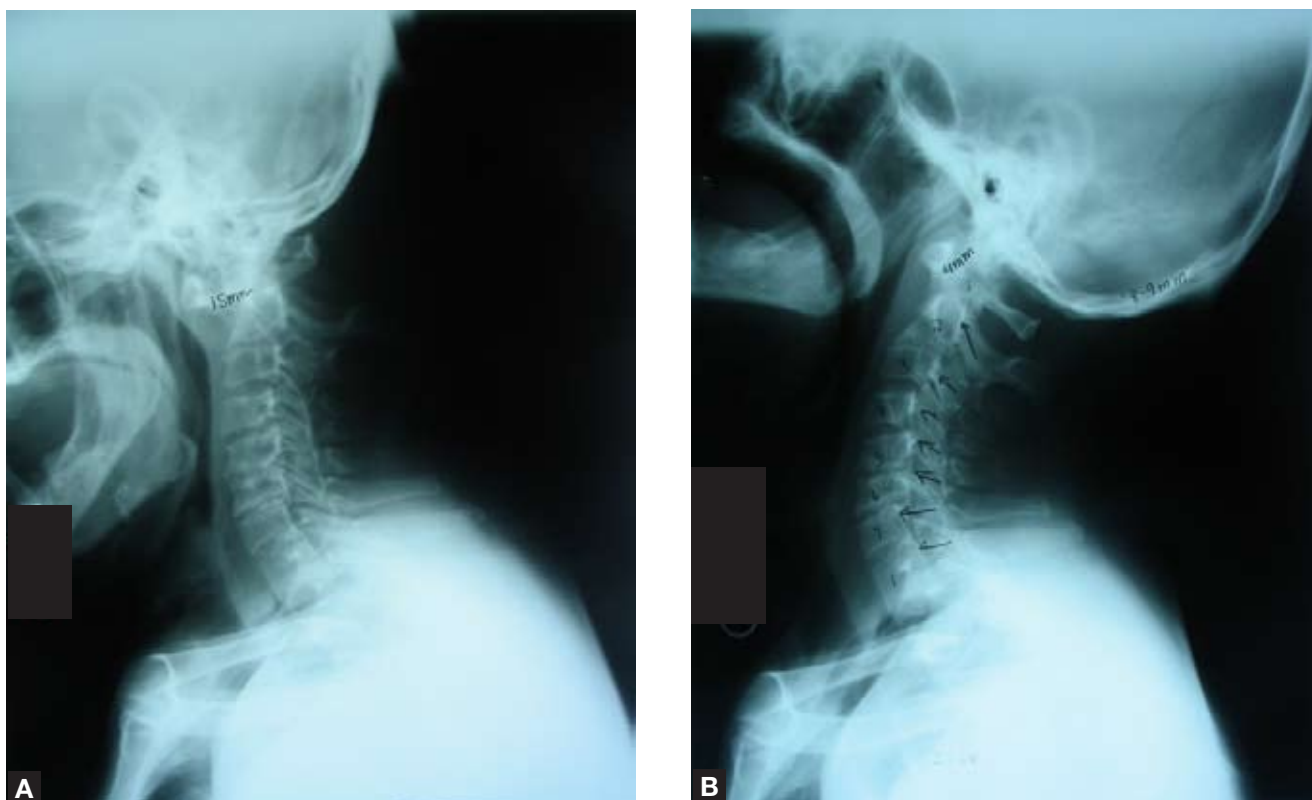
A 56-year-old man with rheumatoid arthritis and cervical myelopathy. Lateral x-rays in flexion (A) and extension (B) show dynamic C1-C2 instability, basilar invagination, and subaxial involvement by the rheumatoid process. Images courtesy of John Olsewski, MD, Bronx, New York.
